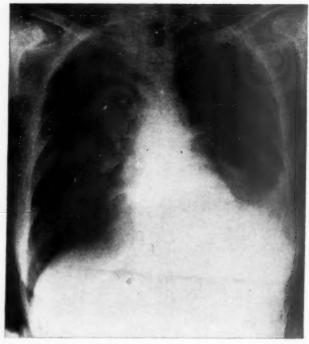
Radiograph of the chest after x-ray therapy February 20, 1958.
